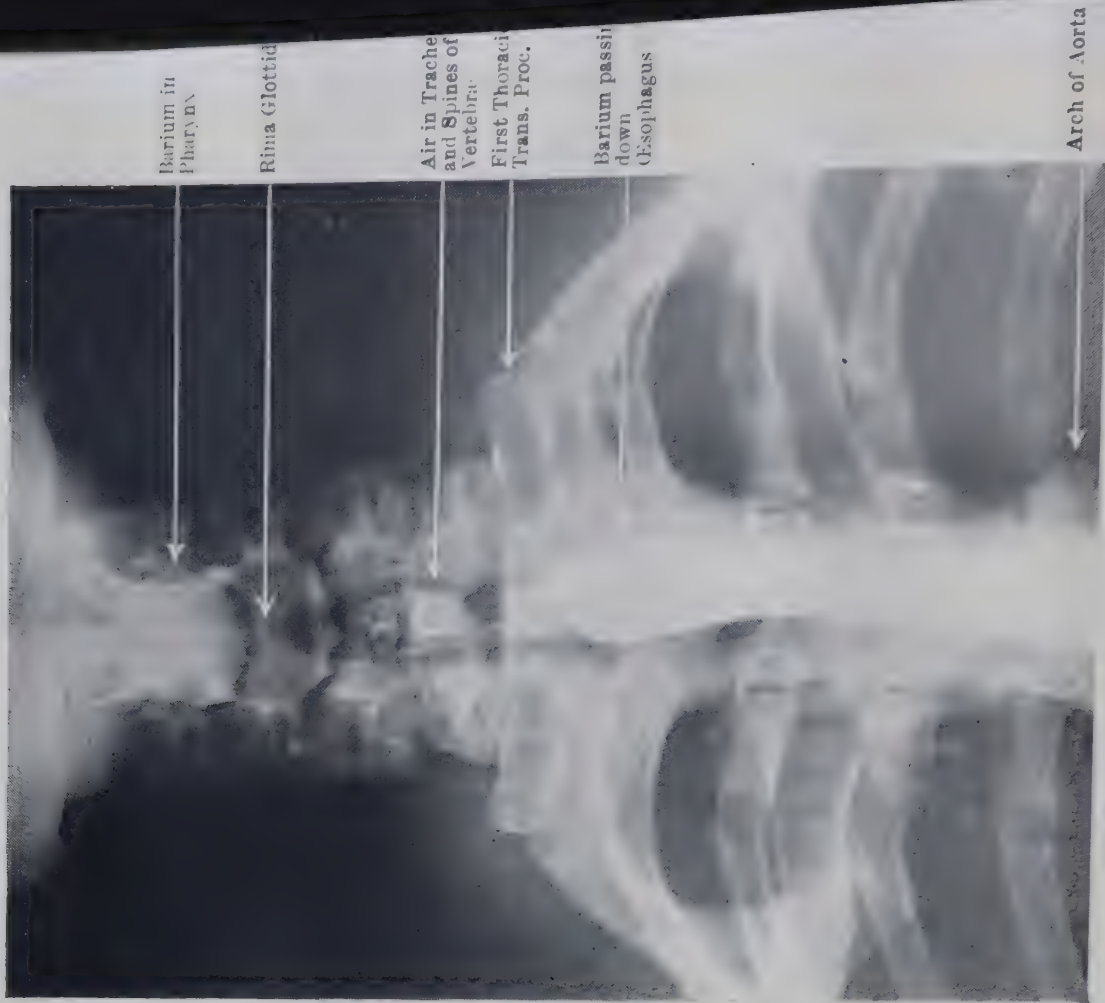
ANTERO-POSTERIOR RADIOGRAPH AS THE BARIUM PASSES INTO THE ESOPHAGUS.
